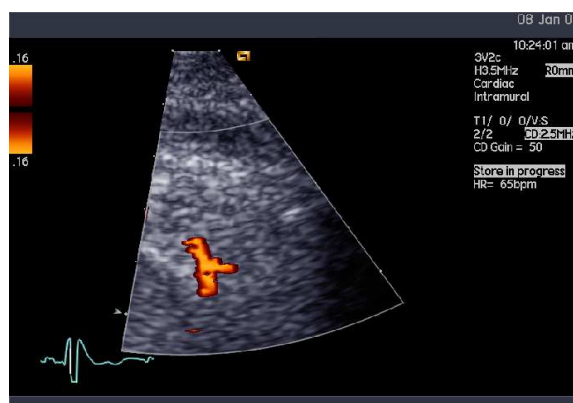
Colour Doppler of the LAD and diagonal branch
